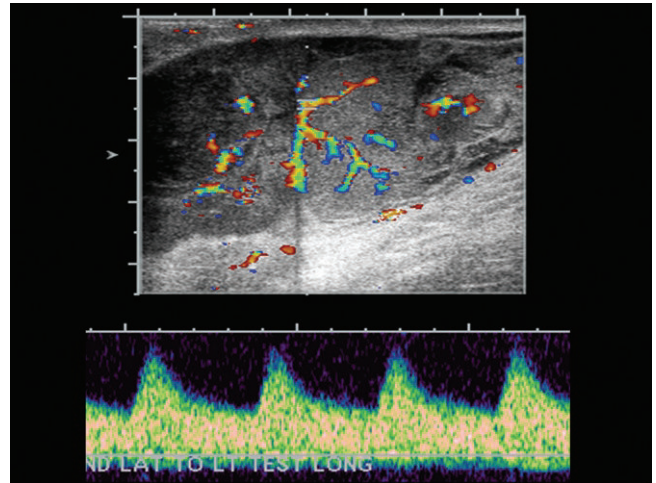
Color Doppler ultrasound was performed demonstrating increased color flow within this extratesticular mass.
